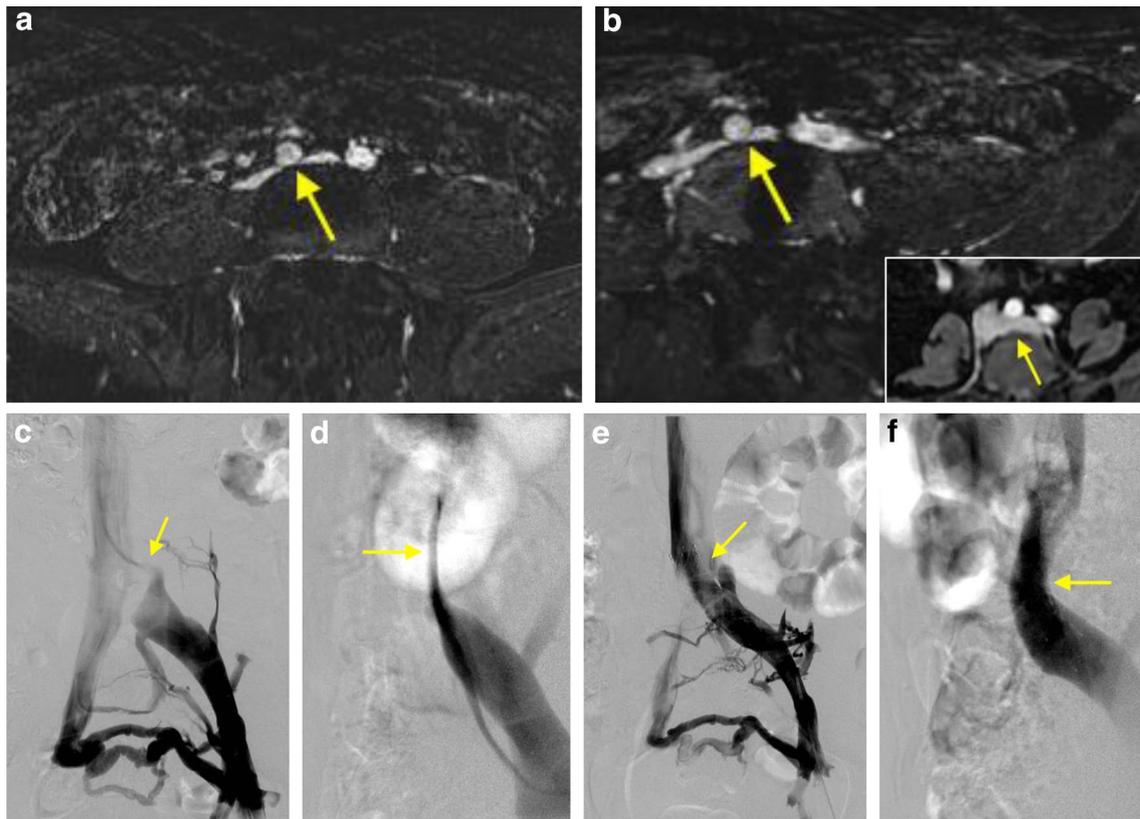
A 37-year-old female with May–Thurner Syndrome. a, b Axial and oblique post-contrast VIBE MR images, respectively, demonstrate severe compression of the left common iliac vein by the right common iliac artery (arrows). For comparison (inset image), VIBE MR images from a different patient show the normal configuration.
